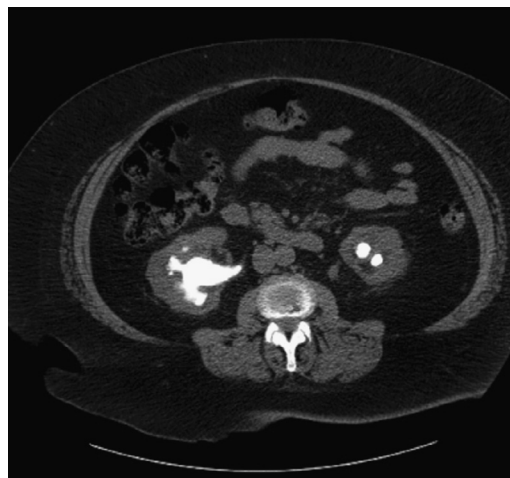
■ Bilateral nephrolithiasis on an unenhanced computed tomography scan. Note the staghorn appearance on the left.
